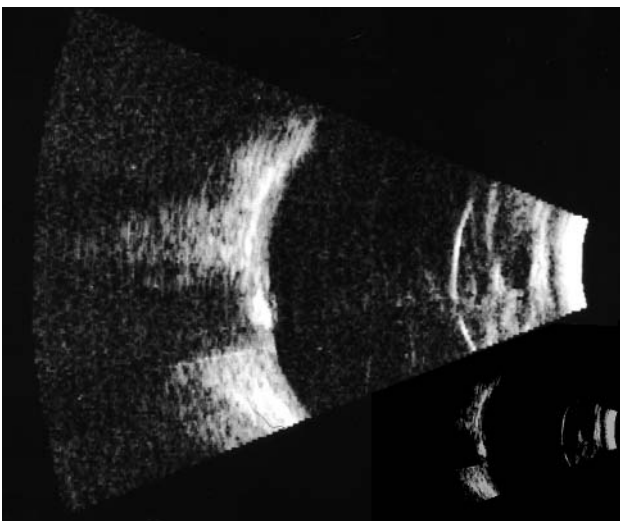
B-scan echography of papillary drusen. The calcium deposits are easily recognizable and remain efficient reflectors of the ultrasound even when imaged with much lower levels of amplification (the *smaller image* at *bottom right*)
